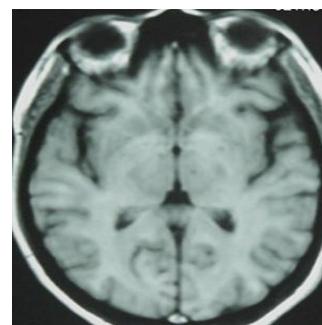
MRI showed a punctiform (lesion hypointense in T1-weighted images) and hyperintense in T2-weighted images in the left thalamus.
